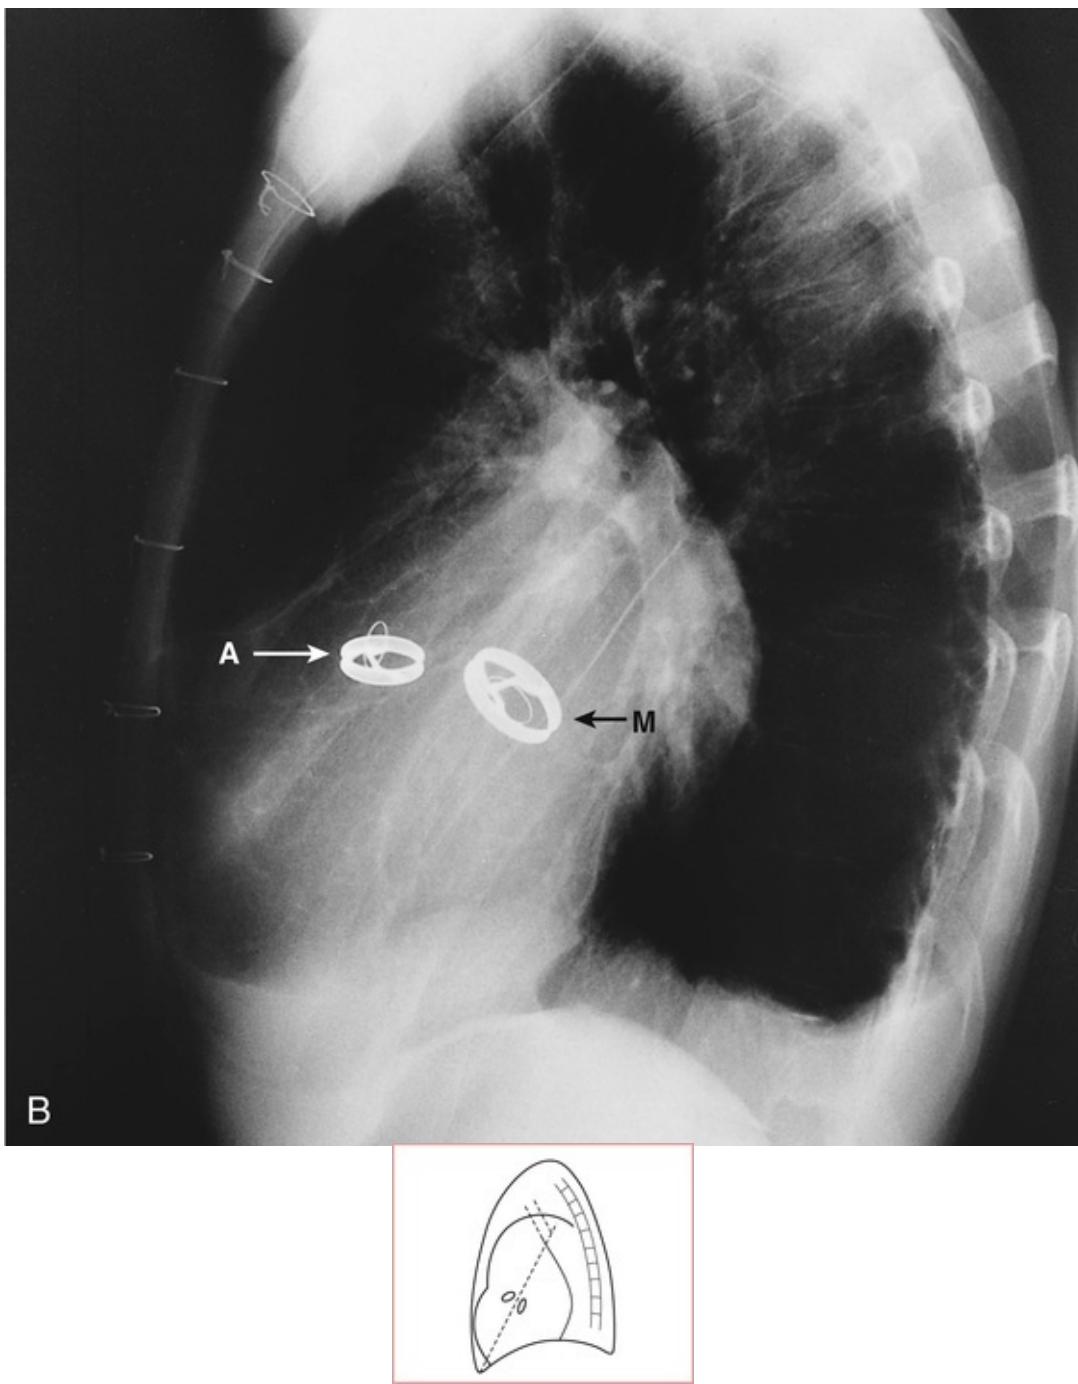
Radiographs of a patient with prosthetic aortic (A) and mitral (M) valves showing their position in the (A) AP and (B) lateral films.
